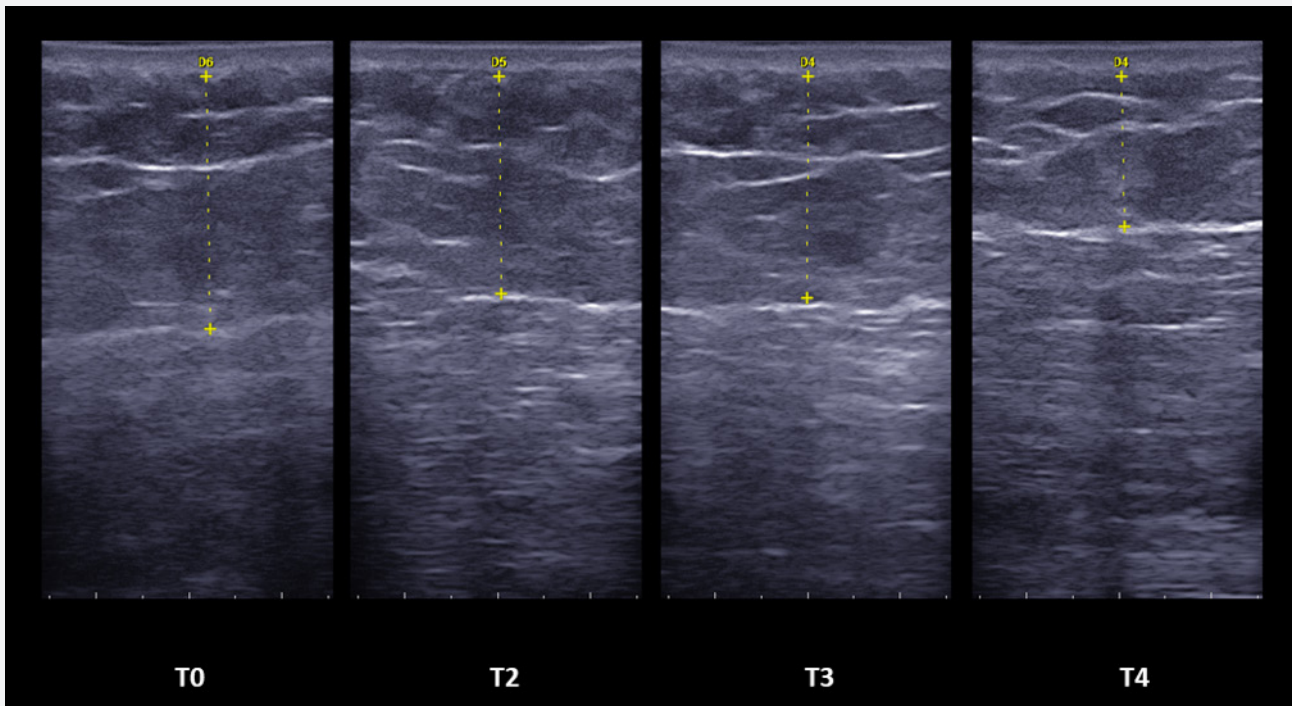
Ultrasound of the left gluteus of a patient at different stages of follow-up with a late but significant improvement after the treatment sessions (T4).
